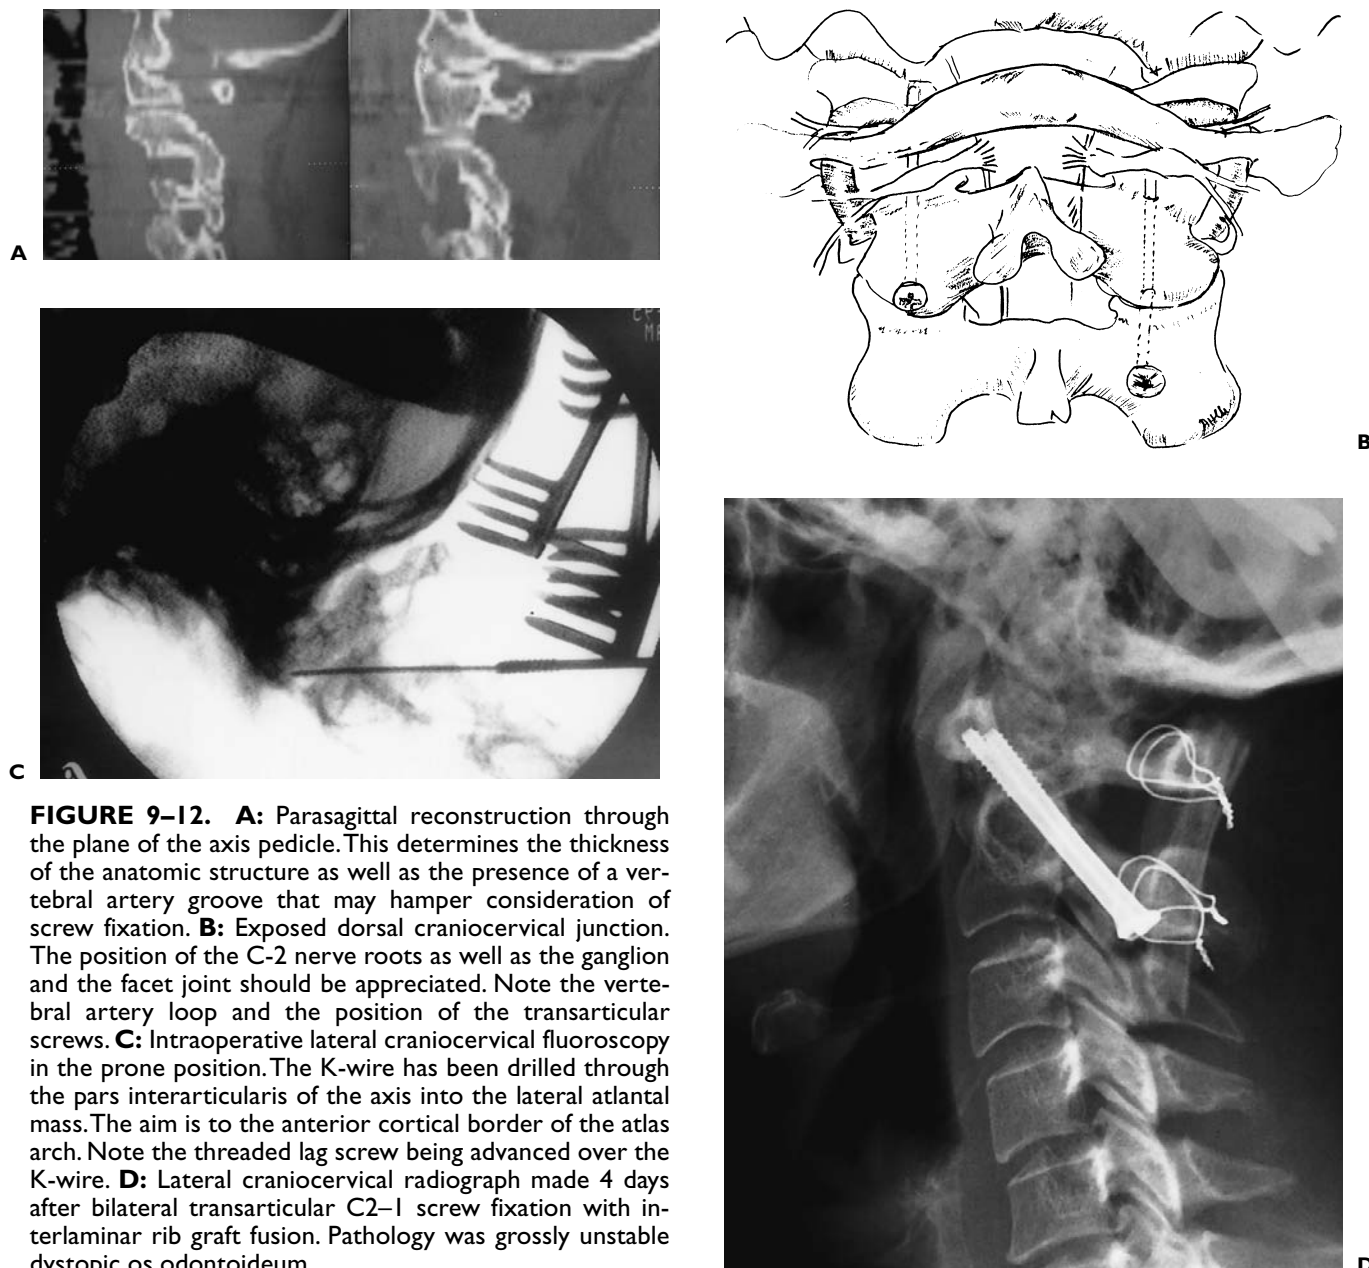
A: Parasagittal reconstruction through the plane of the axis pedicle. This determines the thickness of the anatomic structure as well as the presence of a vertebral artery groove that may hamper consideration of screw fixation. B: Exposed dorsal craniocervical junction. The position of the C-2 nerve roots as well as the ganglion and the facet joint should be appreciated. Note the vertebral artery loop and the position of the transarticular screws. C: Intraoperative lateral craniocervical fluoroscopy in the prone position. The K-wire has been drilled through the pars interarticularis of the axis into the lateral atlantal mass. The aim is to the anterior cortical border of the atlas arch. Note the threaded lag screw being advanced over the K-wire. D: Lateral craniocervical radiograph made 4 days after bilateral transarticular C2-1 screw fixation with interlaminar rib graft fusion. Pathology was grossly unstable dystopic os odontoideum.
